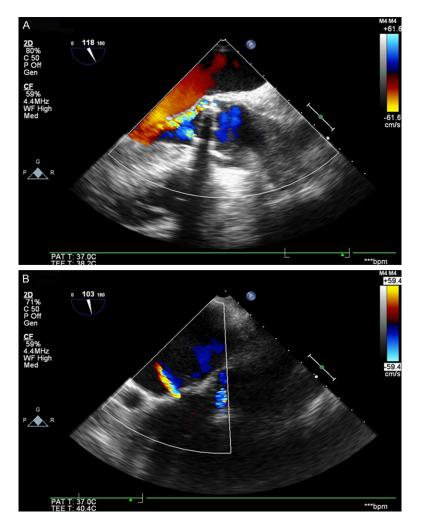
Echocardiography of paravalvular prosthetic regurgitation. A. Transesophageal echocardiogram showing para mitral valve regurgitation. B. Transesophageal echocardiogram showing para aortic valve regurgitation.
